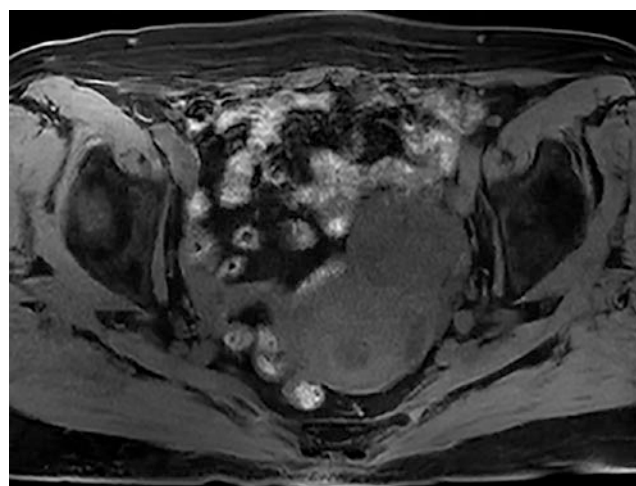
Axial T1-weighted with fat suppression image showed an oval lesion of low signal intensity in the left adnexa area
